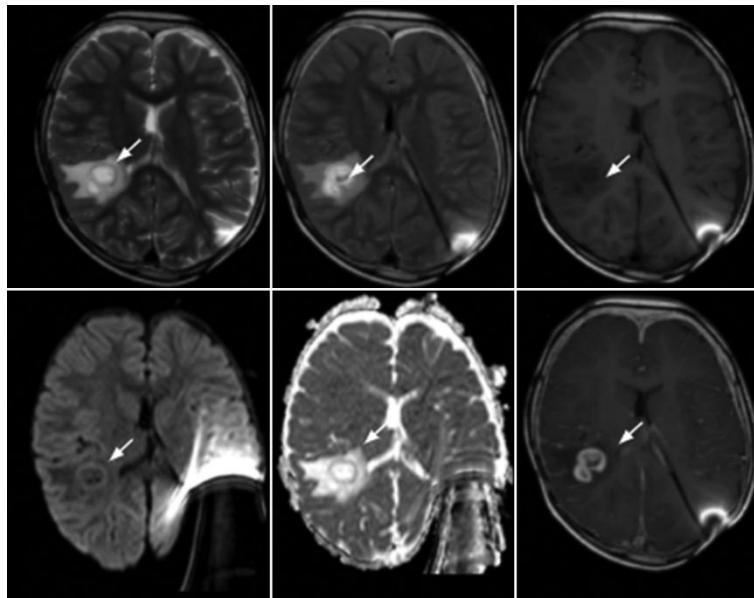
Follow-up MRI three months after the last follow-up, showing progression with greater confluence of T2(A)-FLAIR signal abnormalities (A and B) in the right posterior temporal parenchyma, currently with a cystic lesion showing thickened, irregular, hyperintense margins on T1 (C) with mild diffusion restriction of the wall (D and E) and ring enhancement after intravenous contrast (F)
